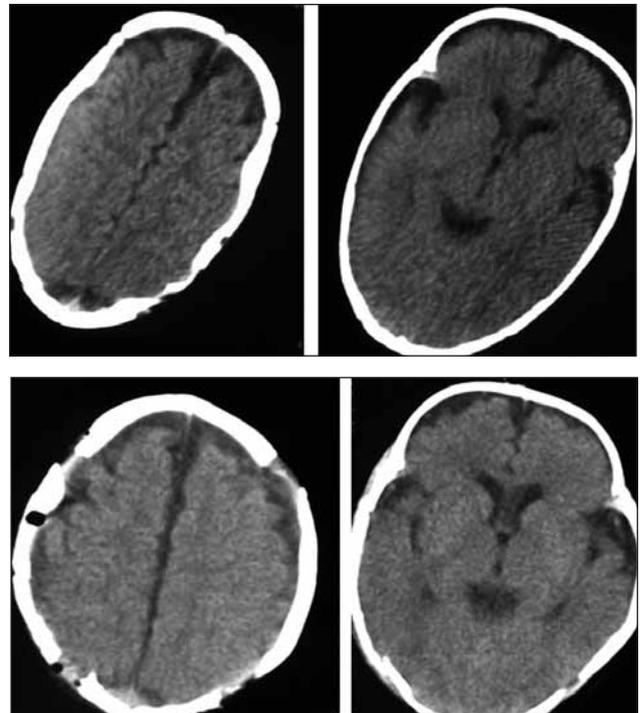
A,B: Preoperative (a) and postoperative (b) CT scans after successful correction of a sagittal craniosynostosis with the described technique.
